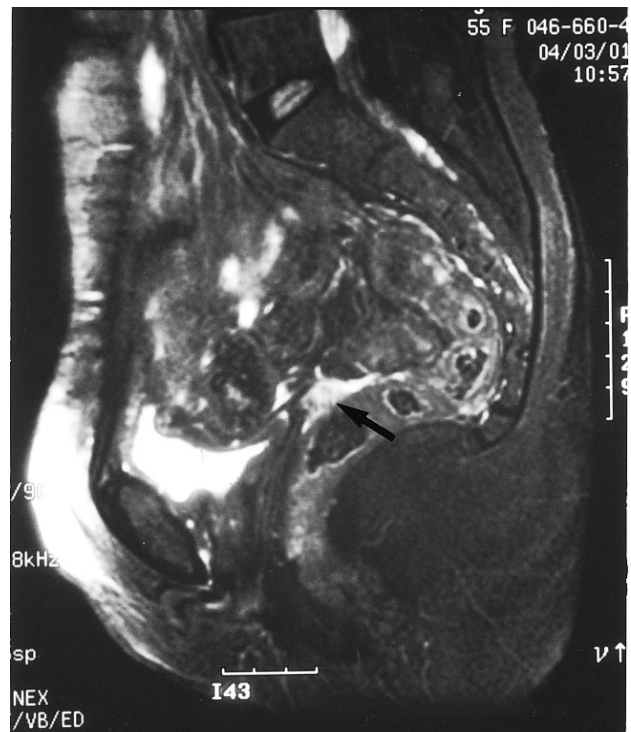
Transsagittal gadolinium-enhanced T1-weighted MRI studies of the pelvic cavity. A relapse lesion was present in the pelvic cavity. Contrast enhancement of the relapse lesion (*arrow*) was heterogeneous, with strong enhancement at the periphery in the pelvic cavity.
